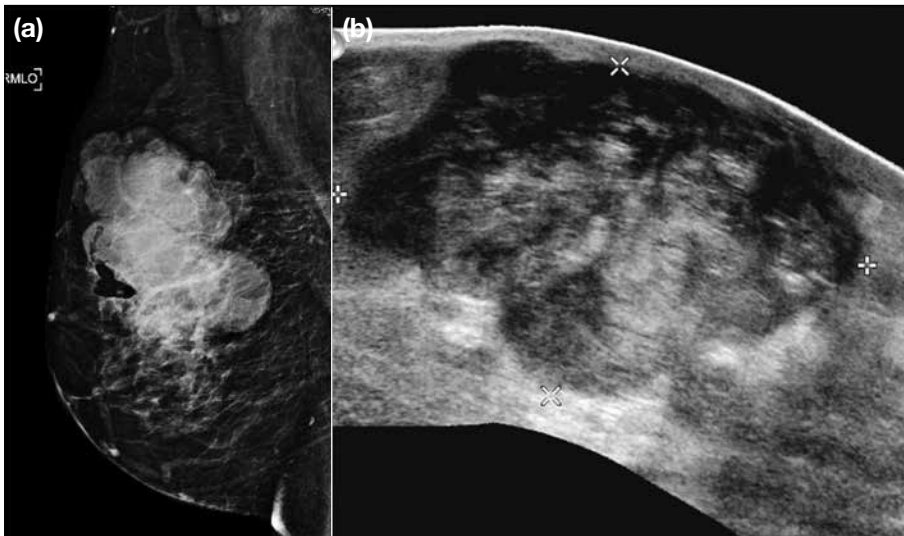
(a) Right mediolateral oblique mammogram of a 62-year-old woman with a large right breast mass showing an irregular equal density breast mass. (b) Ultrasonogram showing that the mass is irregular and predominantly echogenic. Biopsy confirmed a phyllodes tumour with large haemorrhagic component, which explains the large non-vascular echogenic component.
